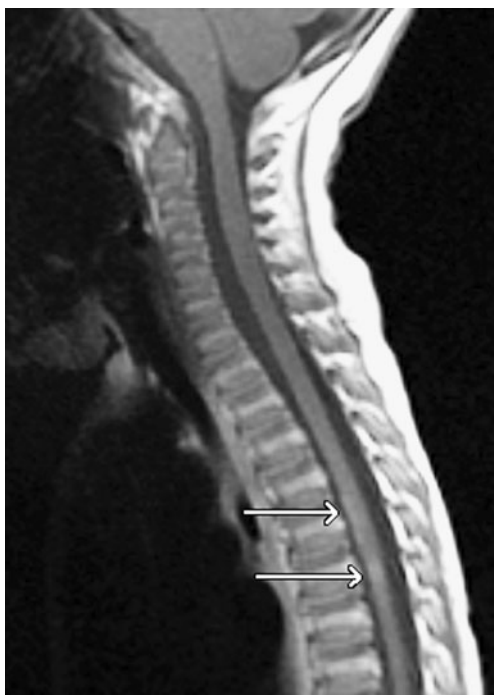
Sagittal T1-W post-gadolinium MR image of the spine demonstrates mild enhancement of the spinal cord at T5 (arrows) and no enhancement within the cervical cord
